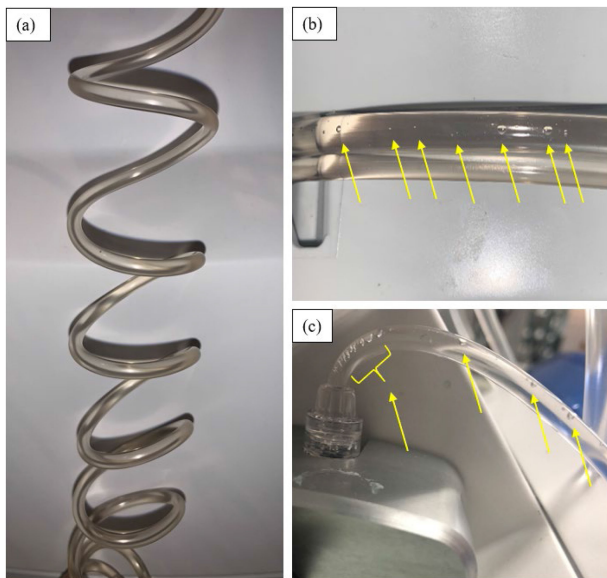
Representative examples of the observed air bubbles, noted by the yellow arrows, that were visible prior to injection in the CT motion and CT Exprès disposables (b, c). As there were no observed instances of visible bubbles in the Centargo disposables, a sample image is provided of the tubing set showing it to be free of bubbles (a).
